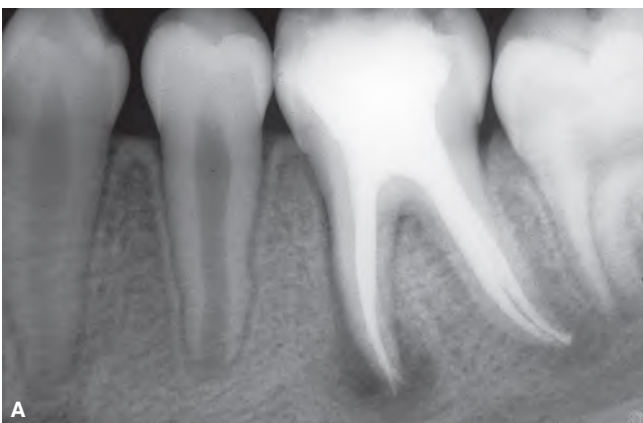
A. Postoperative radiograph following canal obturation of the case shown in Figure 22-1. B. Two-year recall radiograph showing active healing.
